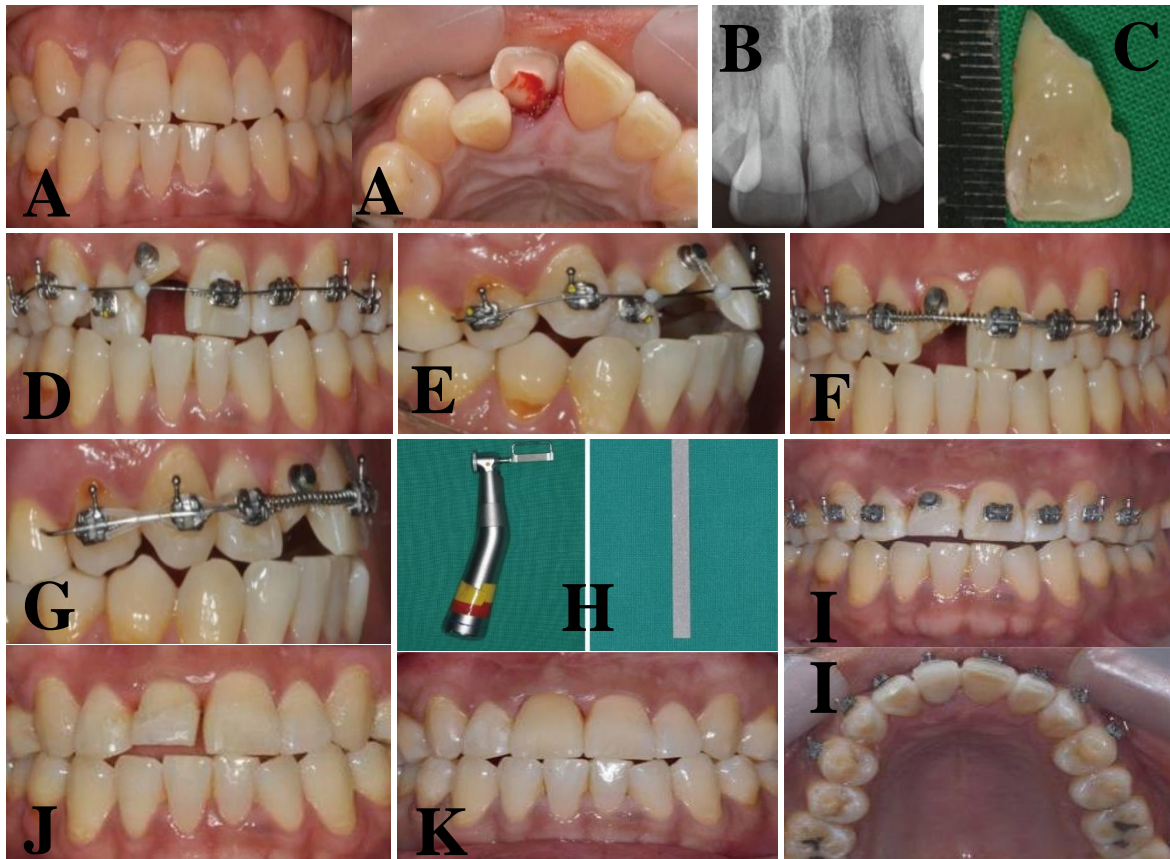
(Kang *et al.*, 2016). A 37-year-old male came to the Department of Conservative Dentistry in Korea, requesting treatment for an injured maxillary right central incisor. patient reported that he fell off a bicycle and injured the tooth 1 day previously. (A, B): Clinical and radiographic examinations showed an oblique crown-root fracture with pulp exposure of the maxillary right central incisor. (C): Fracture line extended approximately 6 mm below the cemento-enamel junction at the mesiopalatal aspect after removing the coronal segment. (D): Treatment plan included orthodontic extrusion, all-ceramic crown restoration of the maxillary right central incisor and orthodontic alignment combined with interproximal reduction of the crowded maxillary anterior teeth. Root canal treatment was completed. (E): Extrusion of the central incisor and labial movement of the lateral incisor were done with elastic threads. (F, G): After 12 weeks of orthodontic treatment, approximately 4 mm of extrusion had been achieved, exposing a good substrate for restoration. In addition, the palatally positioned right lateral incisor was labially re-aligned. In addition, an open coil spring was inserted between the right lateral incisor and the left central incisor to shift the left central incisor and both lateral incisors distally over 4 weeks. (H): Interproximal reduction was performed using an orthostrip (left) and a metal strip (right) on maxillary left central and both lateral incisors. (I): After 16 weeks, an appropriate space for the maxillary right central incisor had been made and a coronal restoration was performed with a fiber post. (J): Additional interproximal stripping was necessary
